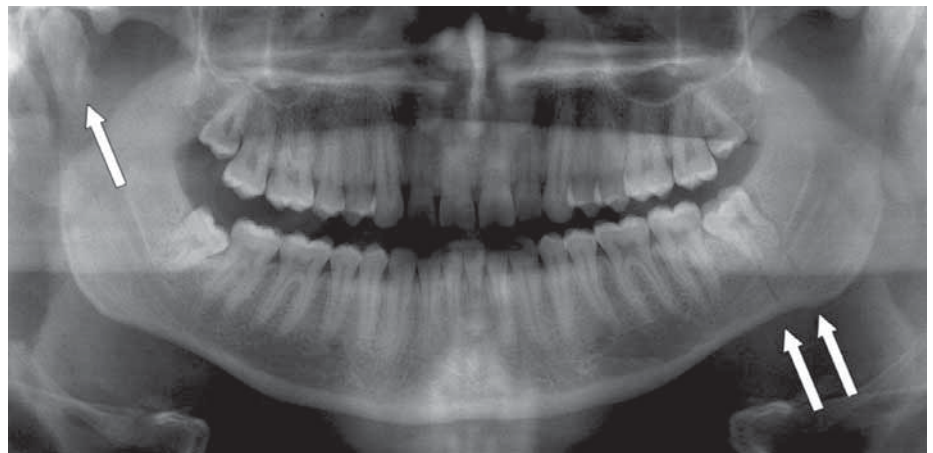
Orthopantomogram showing fracture of left angle and right condyle.
